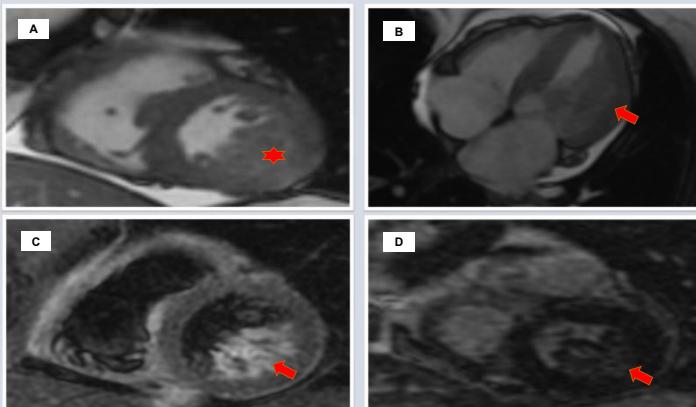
CMR showing the tumor (Red marking) – A: Short-axis; B: Four-chamber; C: T2-weighted - Myocardial edema in heterogeneous mass; D: Late gadolinium enhancement - Heterogeneous mass uptake.
